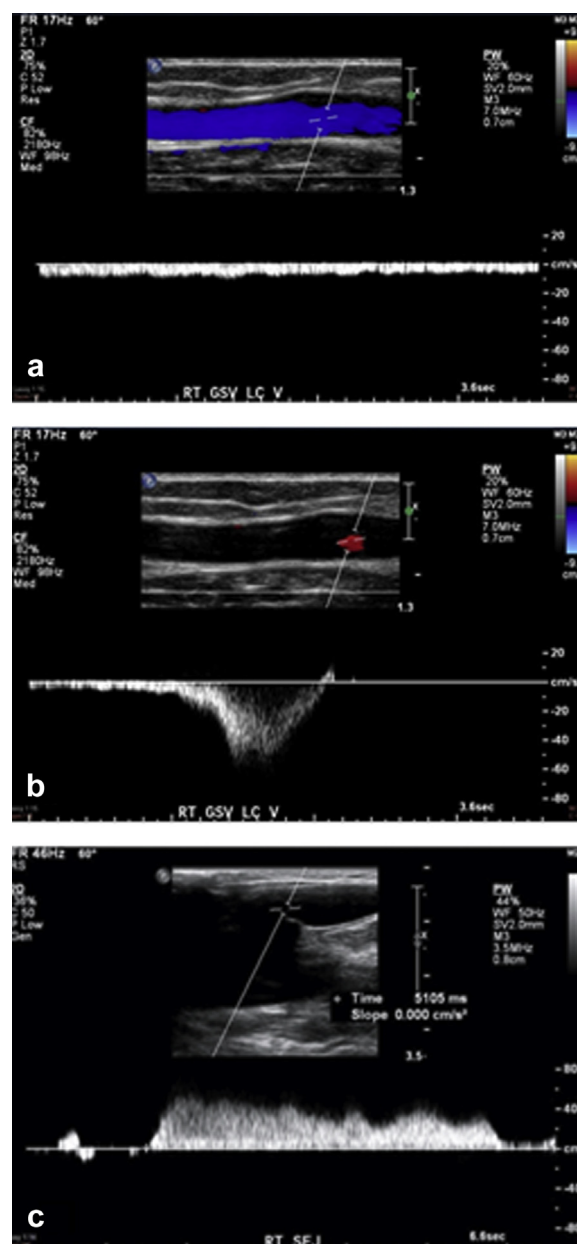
Images of normal and refluxing great saphenous vein (GSV). a, Imaging of the GSV at the lower calf from a male control volunteer. b, The GSV was normal throughout its length. No reflux is seen after release of distal compression. c, Prolonged GSV high-velocity reflux from a female patient who presented with thigh varicose veins (VVs) extending to the calf. Volunteers were selected by ultrasound not to have reflux, whereas the patients had reflux of >2 seconds as shown in this patient.
